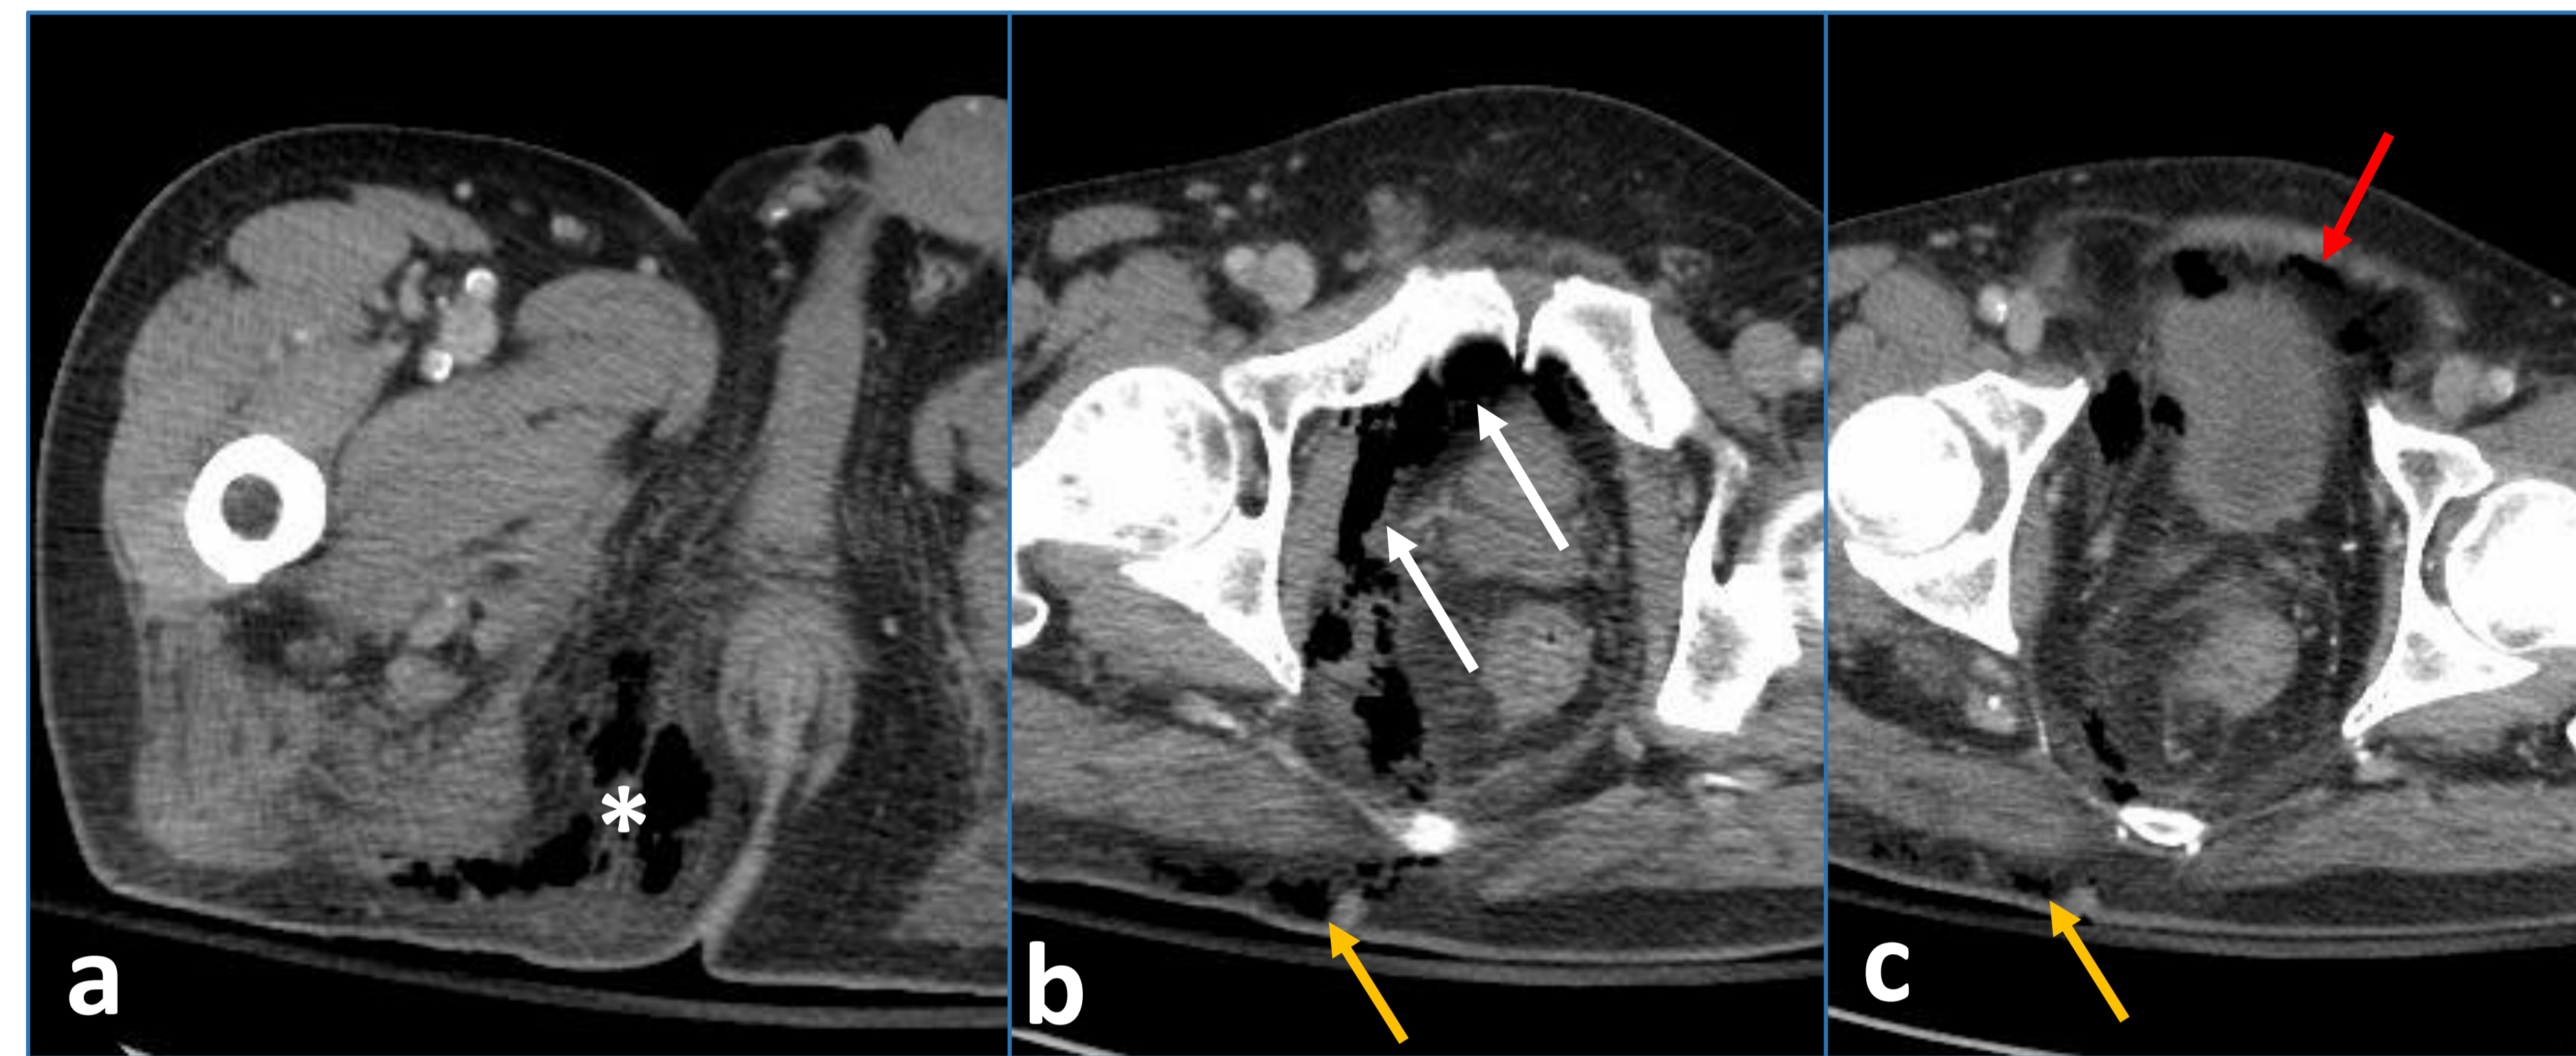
Fournier's gangrene with extraperitoneal spread. a, b and c axial CT images show fat stranding and soft tissue gas at right ischioanal fossa (*) with extension to prevesical space and perivesical space (arrow), extraperitoneal space (red arrow) and buttock (yellow arrow).
